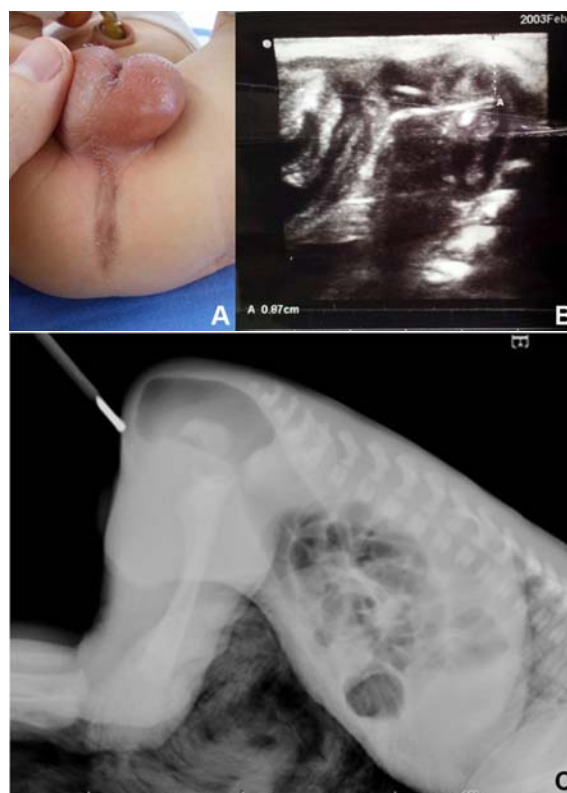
A) A male infant, which was referred to Siriraj Hospital on the first day of life. Physical examination showed ARM without fistula. B) Transperineal ultrasound showed low type ARM which P-P distance was 0.87 mm at 14 hours after birth. C) Rectal gas was presented as low-type anomaly in prone-lateral cross table film at 24 hours after birth.
